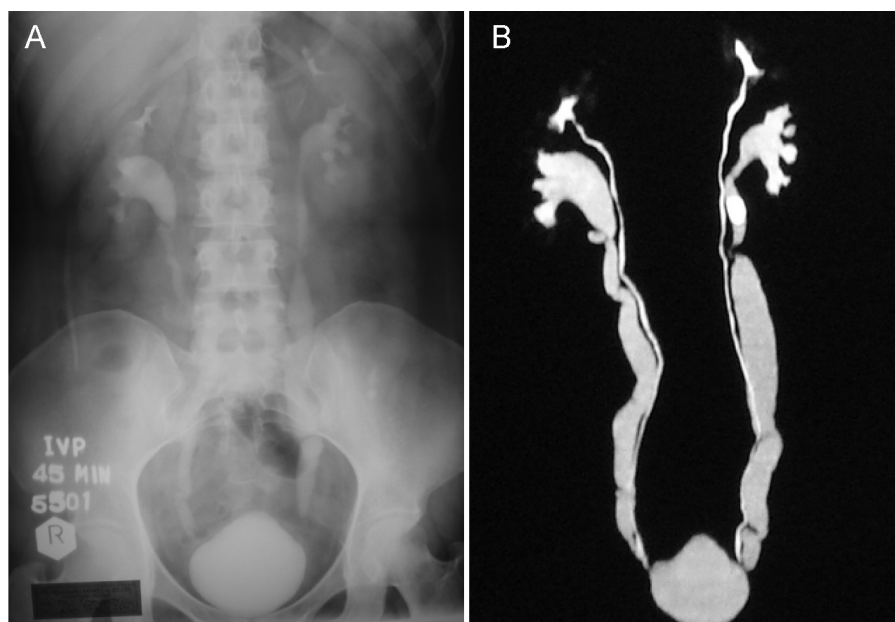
IVP and CT image reconstruction showing filling defect of suspected left upper ureteric stone (A), complete bilateral duplex moiety and a small-capacity bladder (B).
